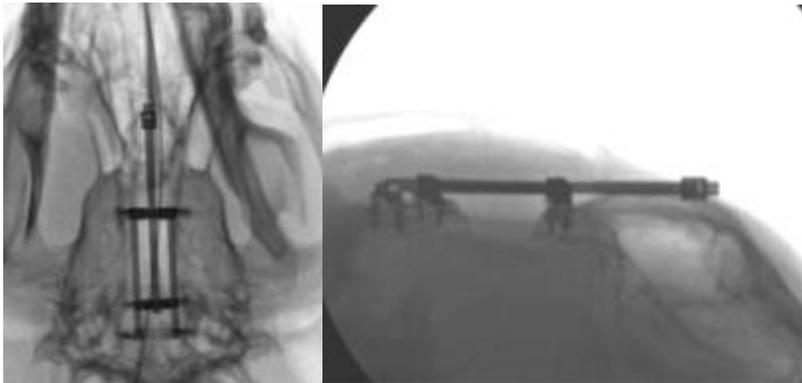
Immediate postoperative plain X-ray. Position of distraction device was checked by this study.
